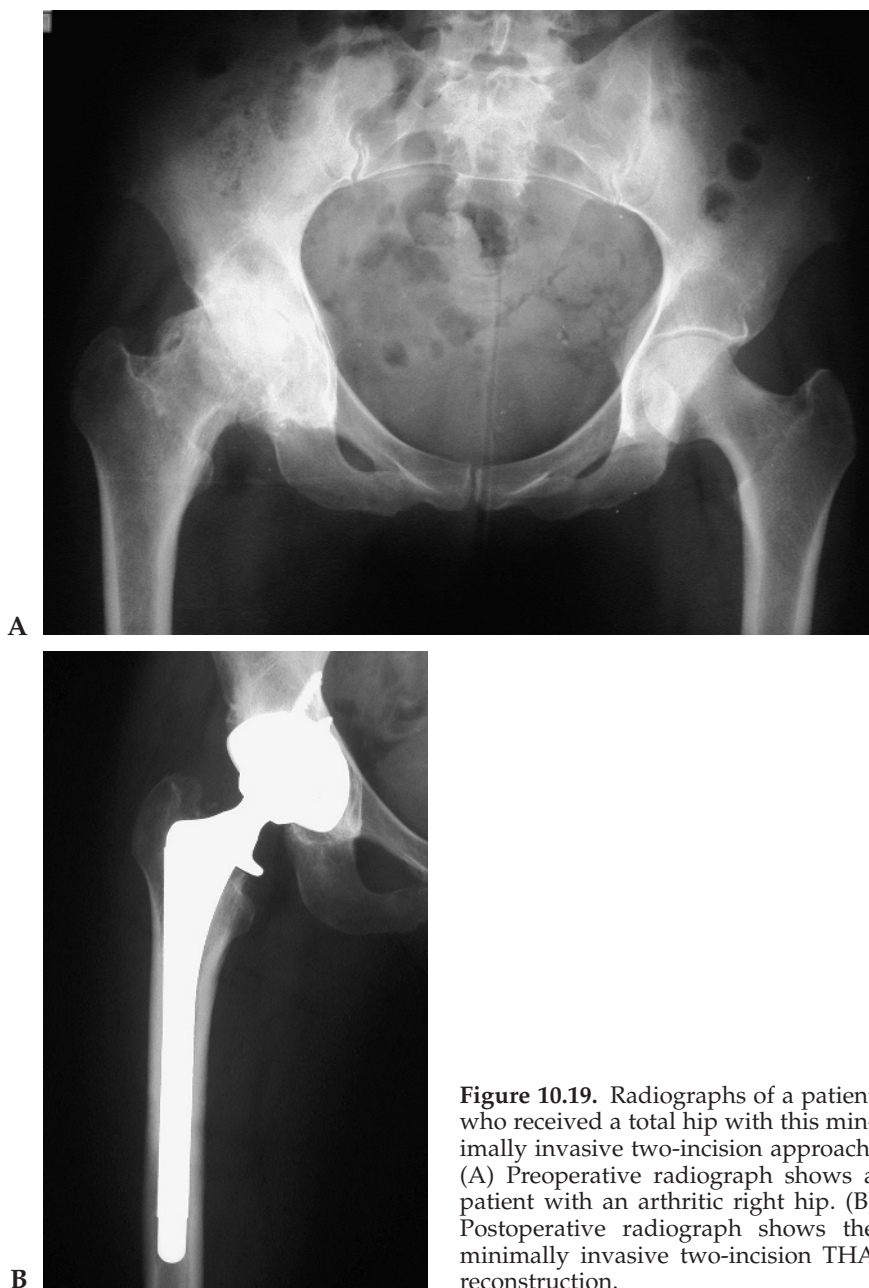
Radiographs of a patient who received a total hip with this minimally invasive two-incision approach. (A) Preoperative radiograph shows a patient with an arthritic right hip. (B) Postoperative radiograph shows the minimally invasive two-incision THA reconstruction.
